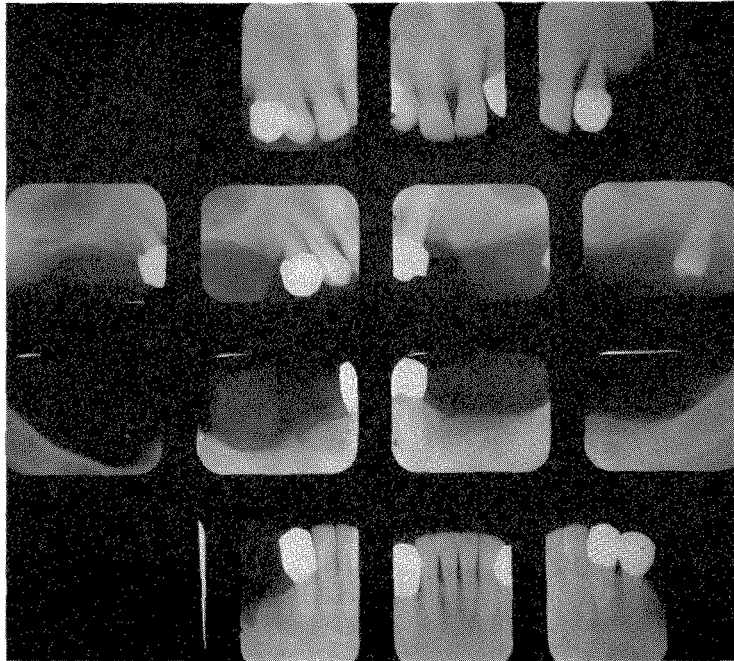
The roentgenograms are shown before the work was started in March, 1956. The prosthesis was inserted in 1956.
